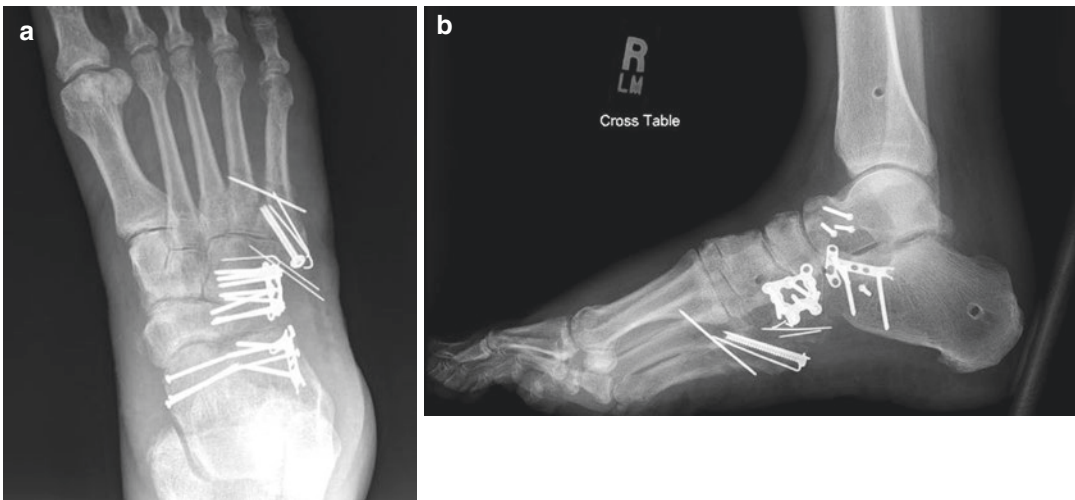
An AP (a) and lateral (b) X-ray demonstrating final fixation of the talar head and lateral column injuries seen in Fig. 22.15a,b
